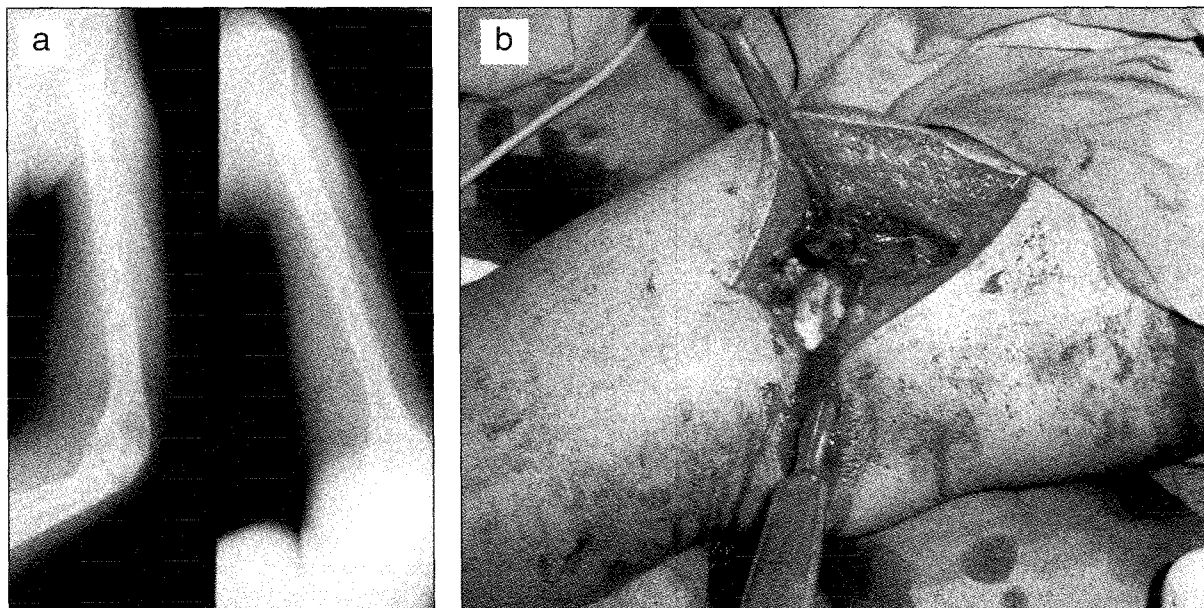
Left: Radiographs of the humerus showing pathological fracture through chronic osteomyelitis segment, Right: Intra-operative finding of thick pus coming out from the medullary cavity.
